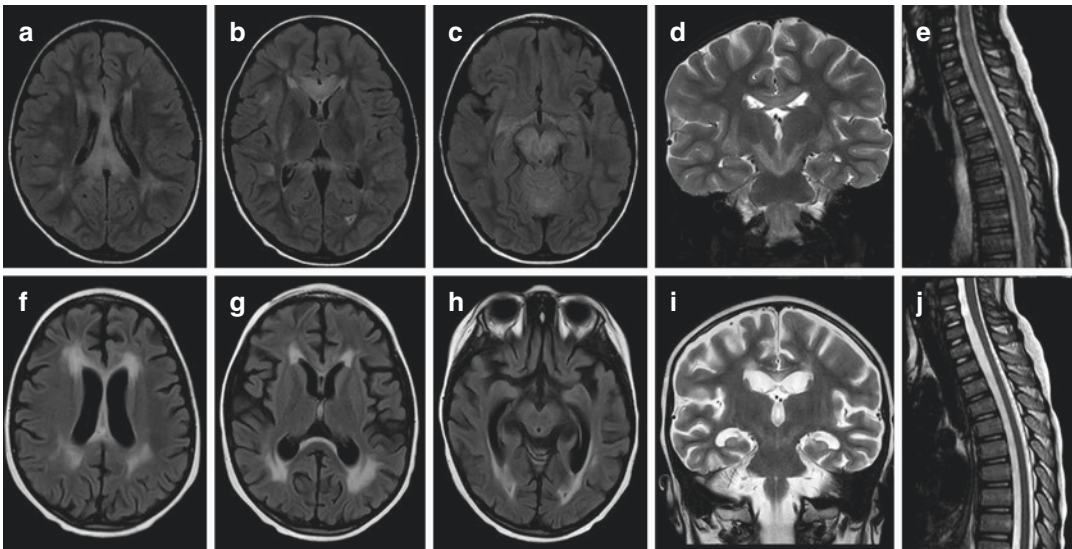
Chemotherapy-induced white matter injury. Evidence of leukoencephalopathy on axial FLAIR-weighted and coronal T2-weighted images of the brain and of myelopathy on sagittal T2-weighted scan of the spinal cord. In the acute phase (a–d), swelling and abnormal signal are observed in the corpus callosum, external capsule, midbrain, and spinal cord (e), due to edema;
